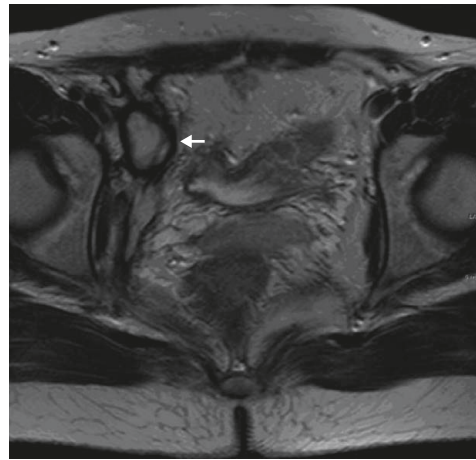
Follow-up magnetic resonance imaging 2 months after embolization showed shrinkage of the hematoma compared with previous images, to about 3 cm in size (arrow).
